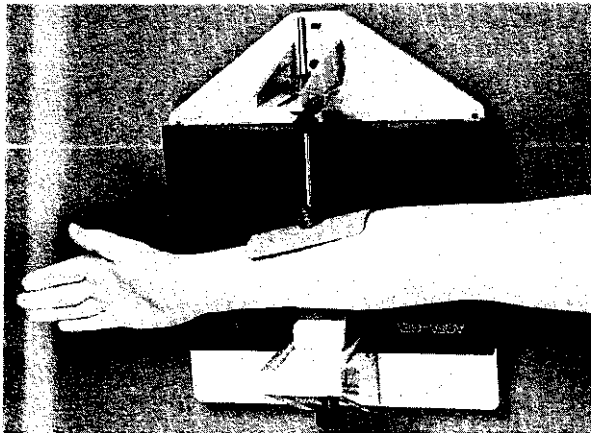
Apparatus for measuring skin thickness radiographically. The x-ray plate is placed behind the forearm and the x-ray is taken from above.
